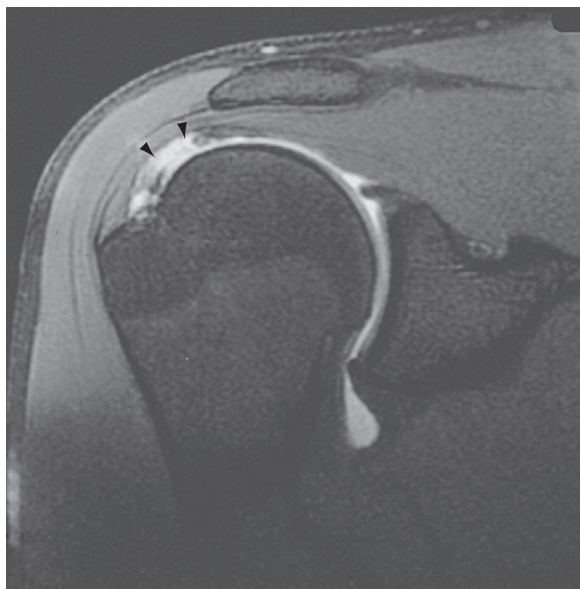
Sagittal section magnetic resonance imaging of the shoulder in a 32-year-old weight lifter complaining of shoulder pain. Fat-suppressed proton density fast spin echo images of bursal-side high-grade partial cuff tear (arrowheads).
